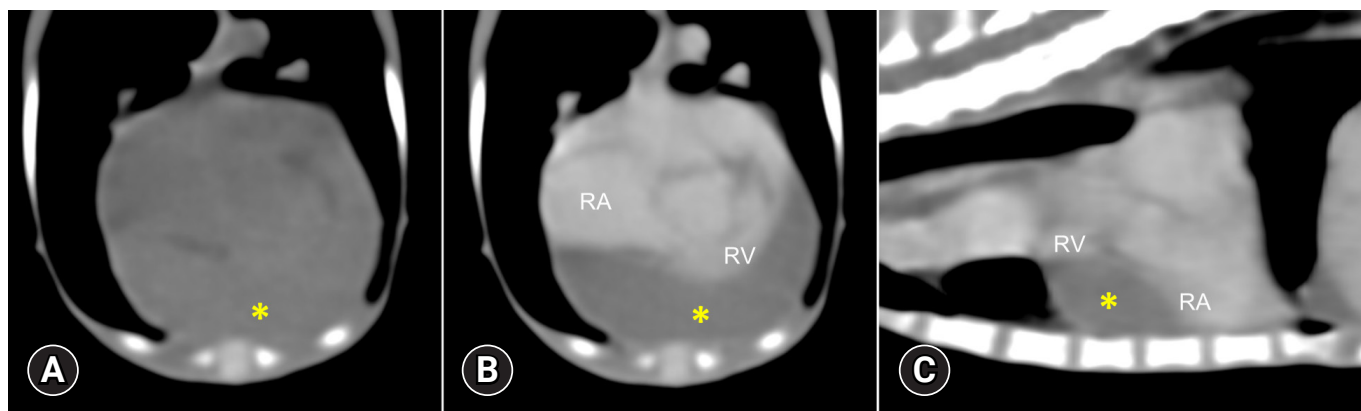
Pre-contrast transverse (A) and post-contrast transverse (B) and sagittal (C) plane computed tomography images. Focal, homogeneously soft-tissue attenuating round structure (yellow asterisk) is noted at the cranioventral part of the right ventricle (RV) and right atrium (RA) compressing the right chamber. This structure does not demonstrate contrast enhancement.
